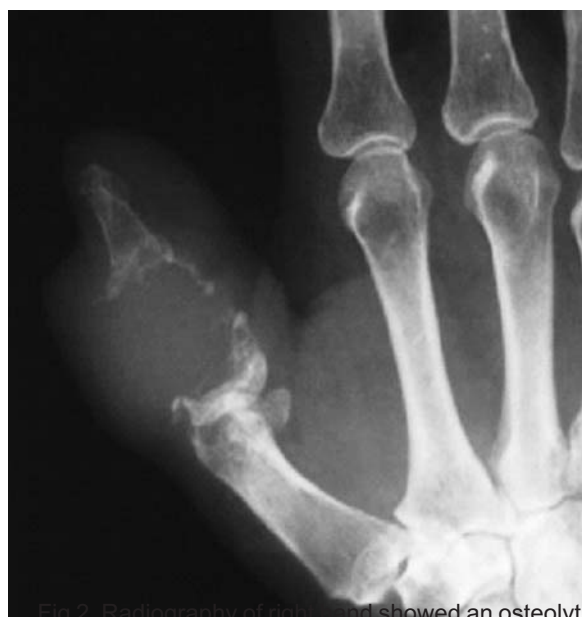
Radiography of right hand showed an osteolytic lesion of thumb proximal phalanx.
